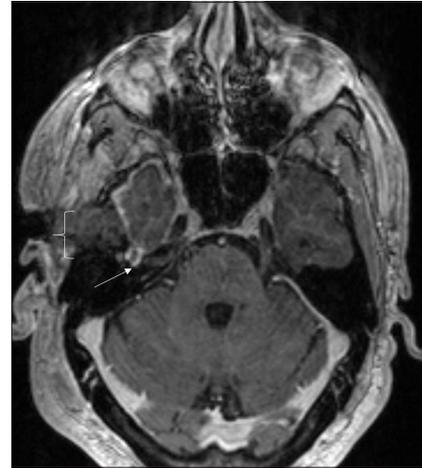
Axial T1-enhanced magnetic resonance imaging demonstrating a defect within the lesion after partial resection (white arrow). Note the right infratemporal craniotomy changes (white bracket).
